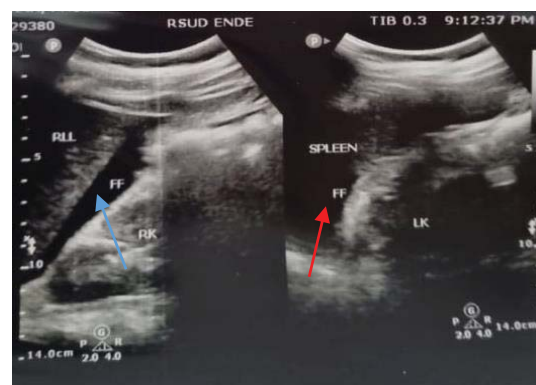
Transabdominal ultrasound demonstrates free fluid in hepatorenal space (blue arrow), splenorenal space (red arrow), and pouch of Douglas, suggesting occurrence of hemoperitoneum.
